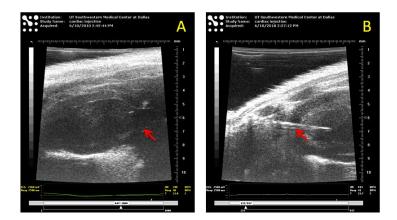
Ultrasound guided intracardiac injection.
